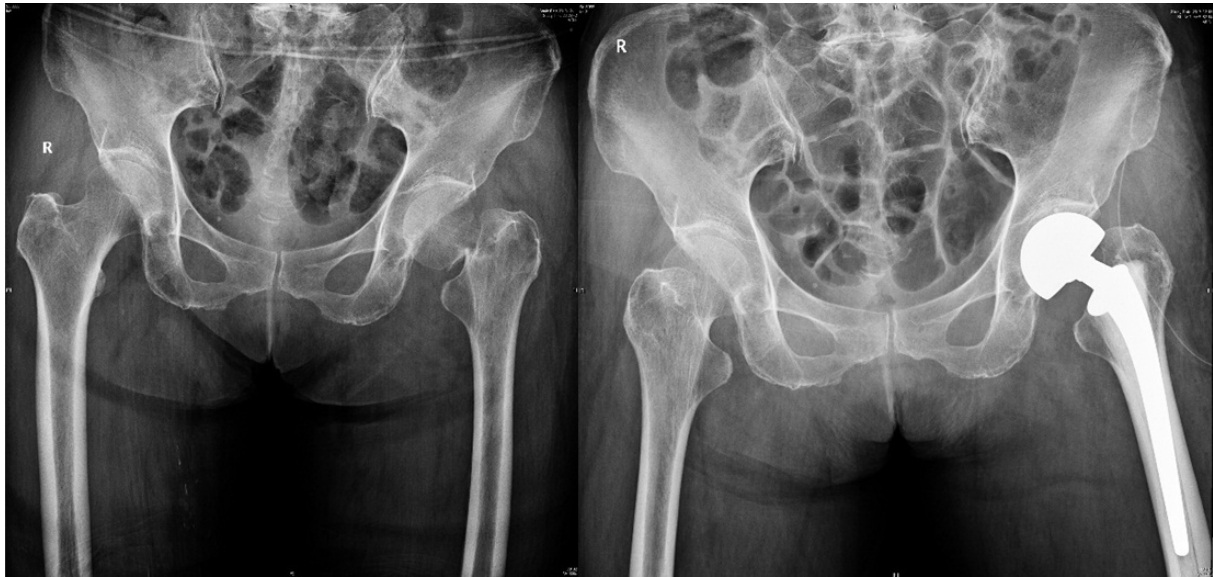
Preoperative X-ray showed left displaced femoral fracture, postoperative X-ray showed the bone cement prostheses.
